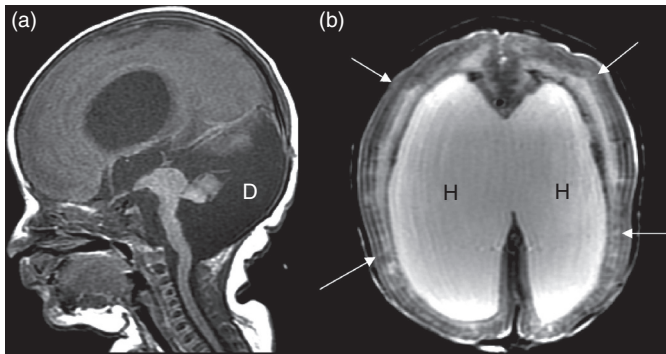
Walker–Warburg with Dandy–Walker malformation (D) on (a) sagittal T1 plus (b) cobblestone lissencephaly (arrows) with extensive white-matter dysplasia and hydrocephalus (H) on axial T2 MRI.
